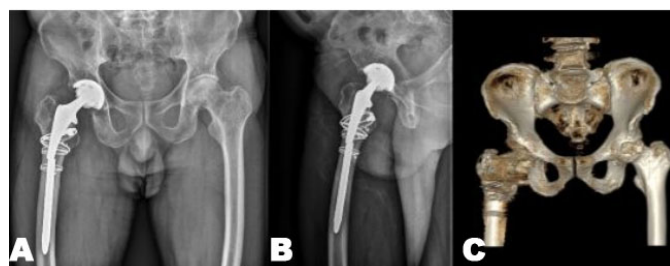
(A) and (B) The frontal and lateral plain radiographs, respectively, after the admission, indicating the fracture in the middle part of the prosthesis; (C) A three-dimensional reconstruction of the computed tomography (CT) of the hip, suggestive of a loss of bone mass in the right proximal femur.
